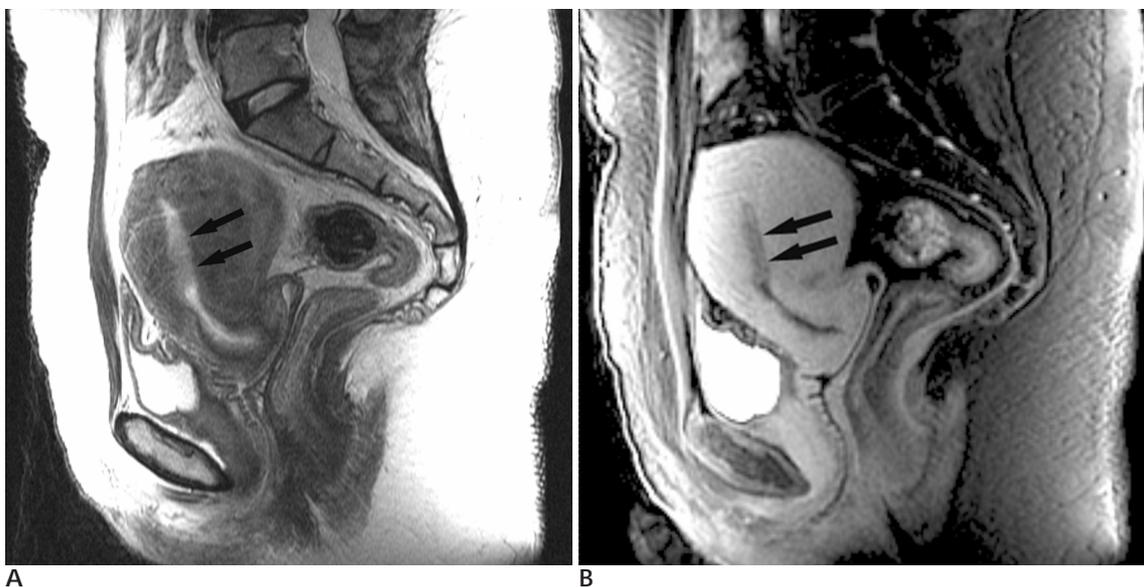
A 48-year-old woman with spontaneous endometrial cancer. A. The sagittal T2-weighted image shows the hyperintense thickened lesion of the endometrium (arrows). B. The contrast-enhanced gradient echo sagittal T1-weighted image demonstrates the homogenous enhancing endometrial cancer (arrows) with an intact junction zone.
